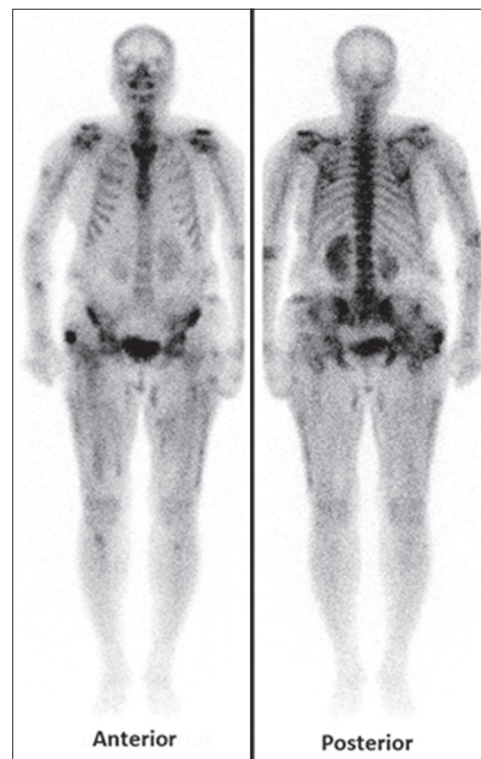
Tc-99m-methylene diphosphonate whole-body bone scintigraphy in anterior and posterior projections showing multiple areas of irregular tracer deposition in the soft tissues of right upper limb, left arm, in the bilateral gluteal region, anterior and posterior aspects of the thighs and anterior aspect of bilateral proximal part of leg
